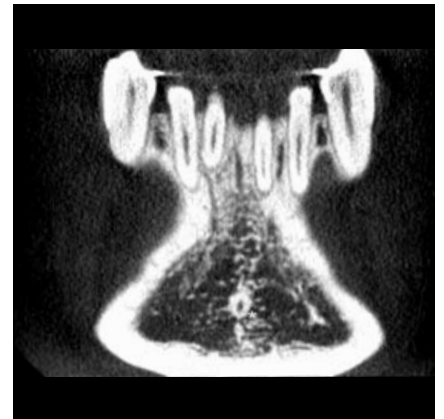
Coronal CBCT image
